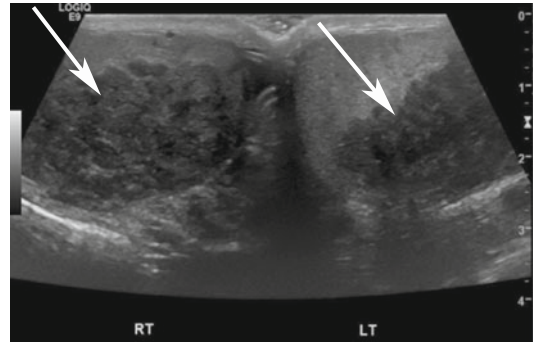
Scrotal ultrasound images of a 21-year-old man with known congenital adrenal hyperplasia on follow-up show bilateral adrenal rests in both testicles (arrows). Without the clinical history, malignancy would have been the most likely diagnosis
